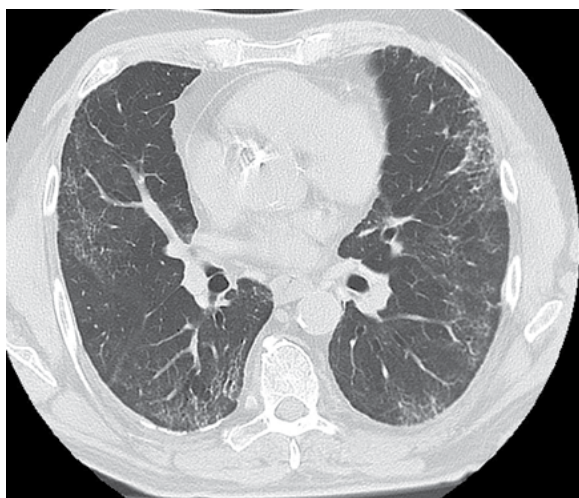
Chest CT 7 months later (COVID-19 1/18/2021, CT 8/16/2021)
